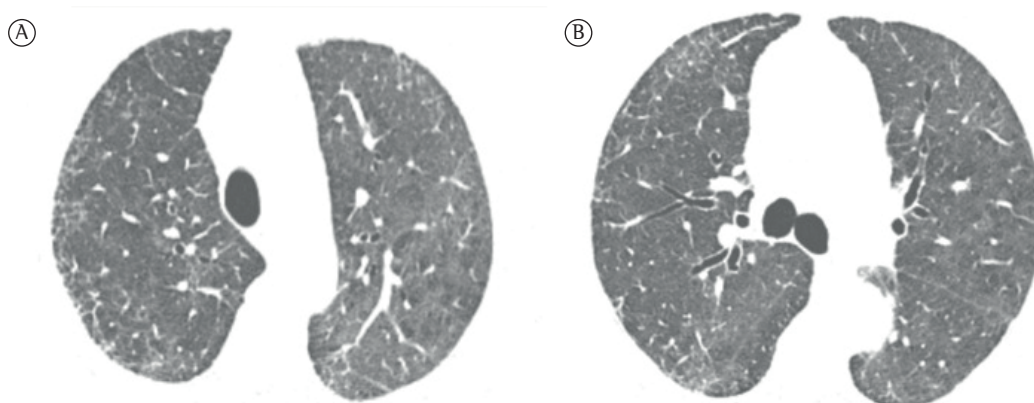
HRCT scan of the chest performed three weeks after the onset of the condition. A comparative analysis of the slices shows significant spontaneous improvement in the ground-glass opacities, in relation to the first scan, in the upper lung fields, in A, and at the level of the main carina, in B. There remain faint ground-glass opacities together with slight reticular infiltrates in the subpleural regions, predominantly in the right hemithorax, especially in the middle lobe.
